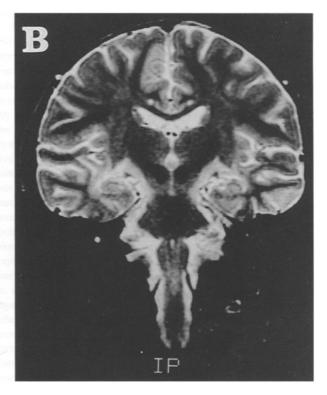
MR images of the present case. A: the parieto-occipital white matter in the T2-weighted, 2500/100, axial image shows markedly high intensity. B: the pyramidal tracts, including the cerebral peduncles and the corticospinal tracts in the pons, in the T2-weighted, 2500/100, coronal image are not involved.
